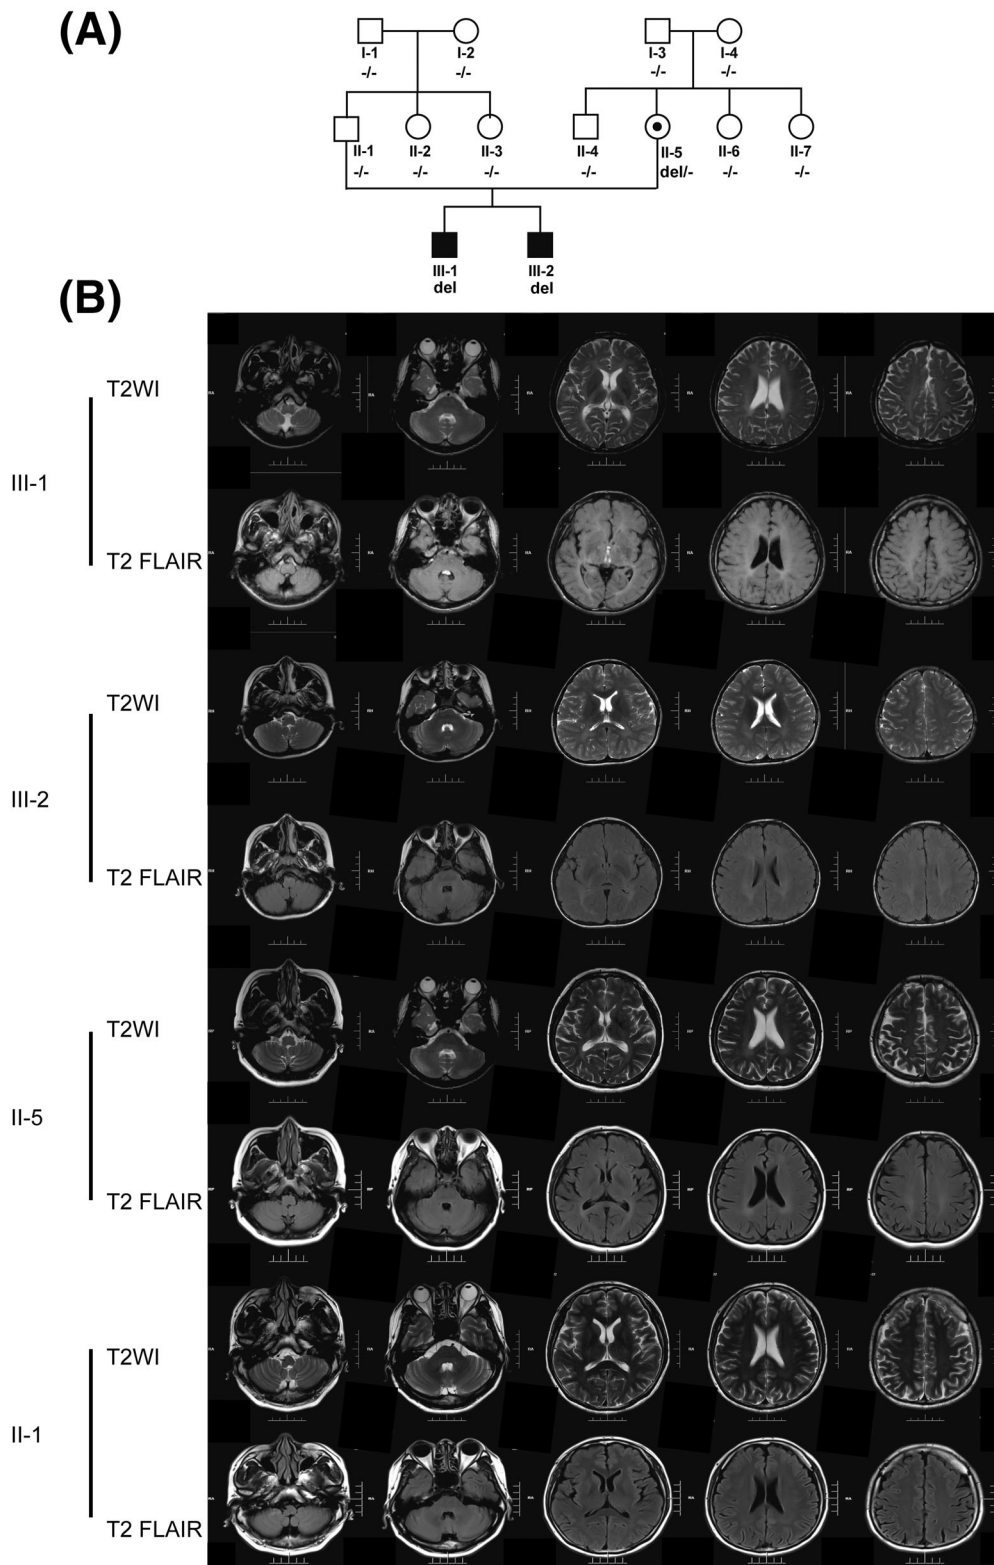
(A) Family tree. (B) T2-weighted image (T2WI) and fluid-attenuated inversion recovery (FLAIR) revealed symmetric, diffuse hyperintensity in the periventricular white matter and the posterior limbs of the internal capsule in III-1, III-2, and II-5. Brain atrophy is shown in III-1, and II-5 presented normal brain MRI.
